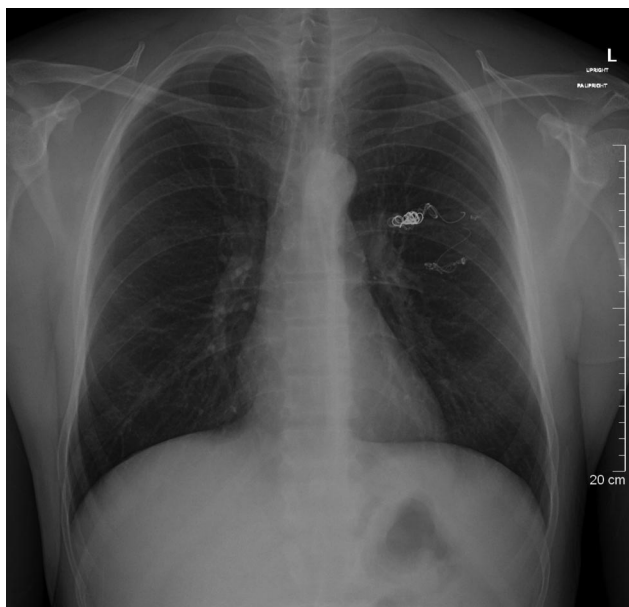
Chest radiograph following embolization of the pulmonary arteriovenous malformation shows multiple coils and almost complete disappearance of the left-upper-lobe mass.
